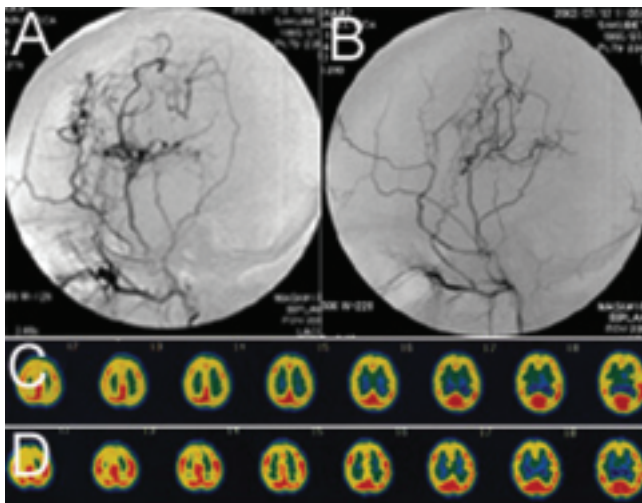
Right (A) and left (B) external carotid artery angiograms obtained in the patient in July 2002 demonstrating extensive blood supply to the brain via a bypass. A postoperative  $^{99m}\text{Tc}$ -ECD SPECT study obtained on the same day shows the recovery of rCBF (C) and rCVR (D) in the bilateral frontal lobes.
